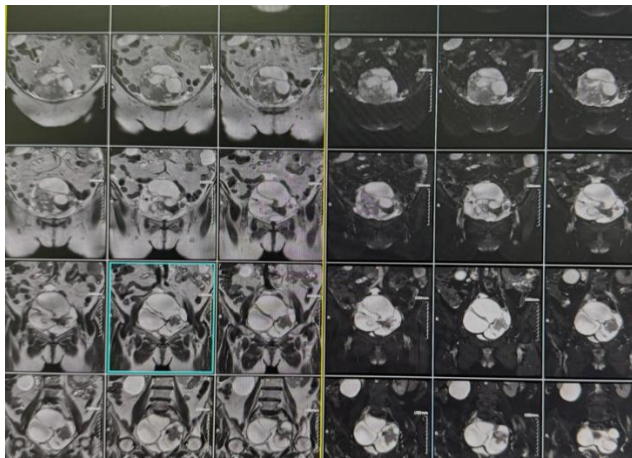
Contrast-enhanced MRI showing large complex solid-cystic pelvic mass measuring approximately 20 cm suggestive of malignant epithelial ovarian tumour.
